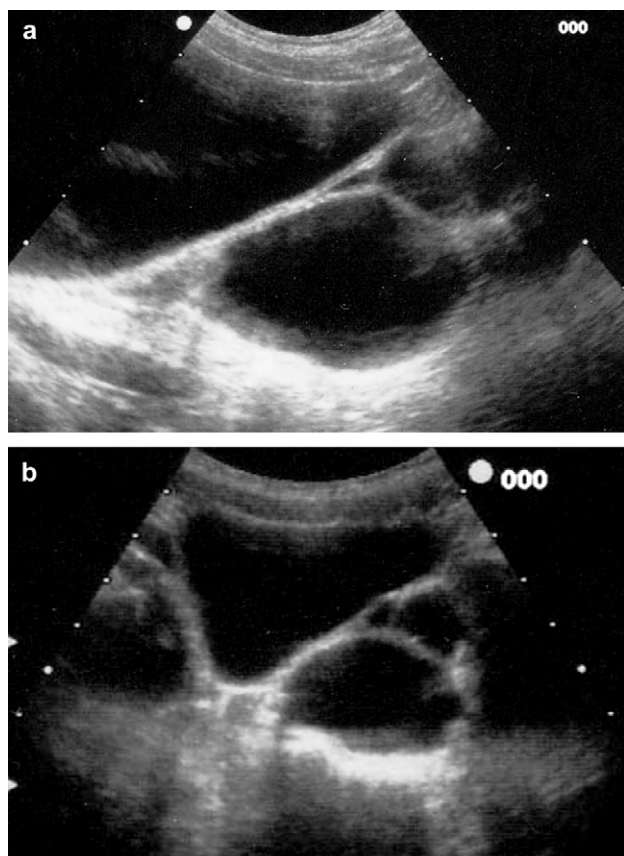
(a) Ultrasound scan showing the presence of a retro-vesical cyst compressing the bladder neck in the sagittal view. (b) Post-micturition residue in the longitudinal view.
